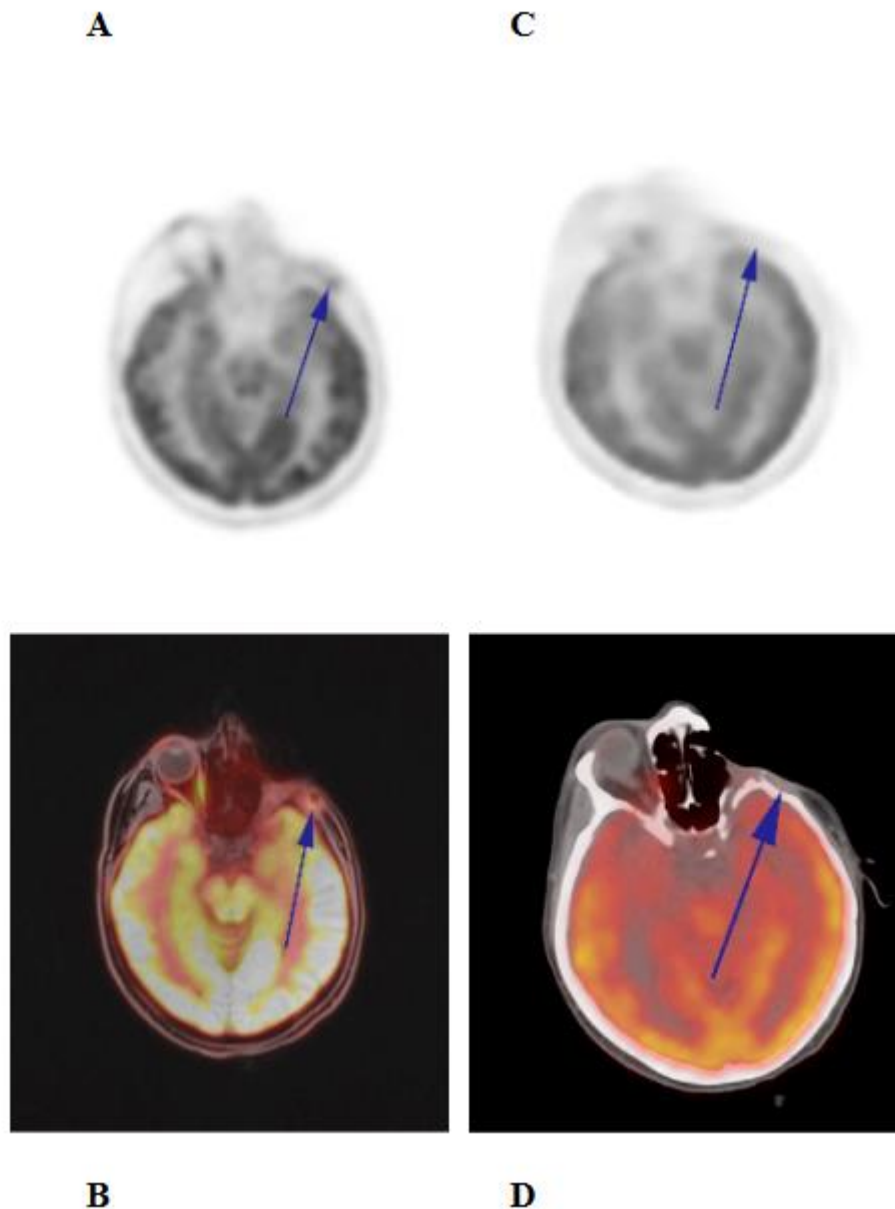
The PET/CT images showing marked tumor regression (A, C) and showing no pathologic FDG uptake (B, D) following the treatment.
